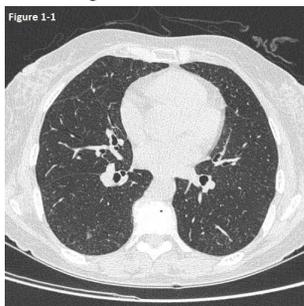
Serial chest CT images revealed a progressively increasing GGO nodule in the superior segment of RLL.
